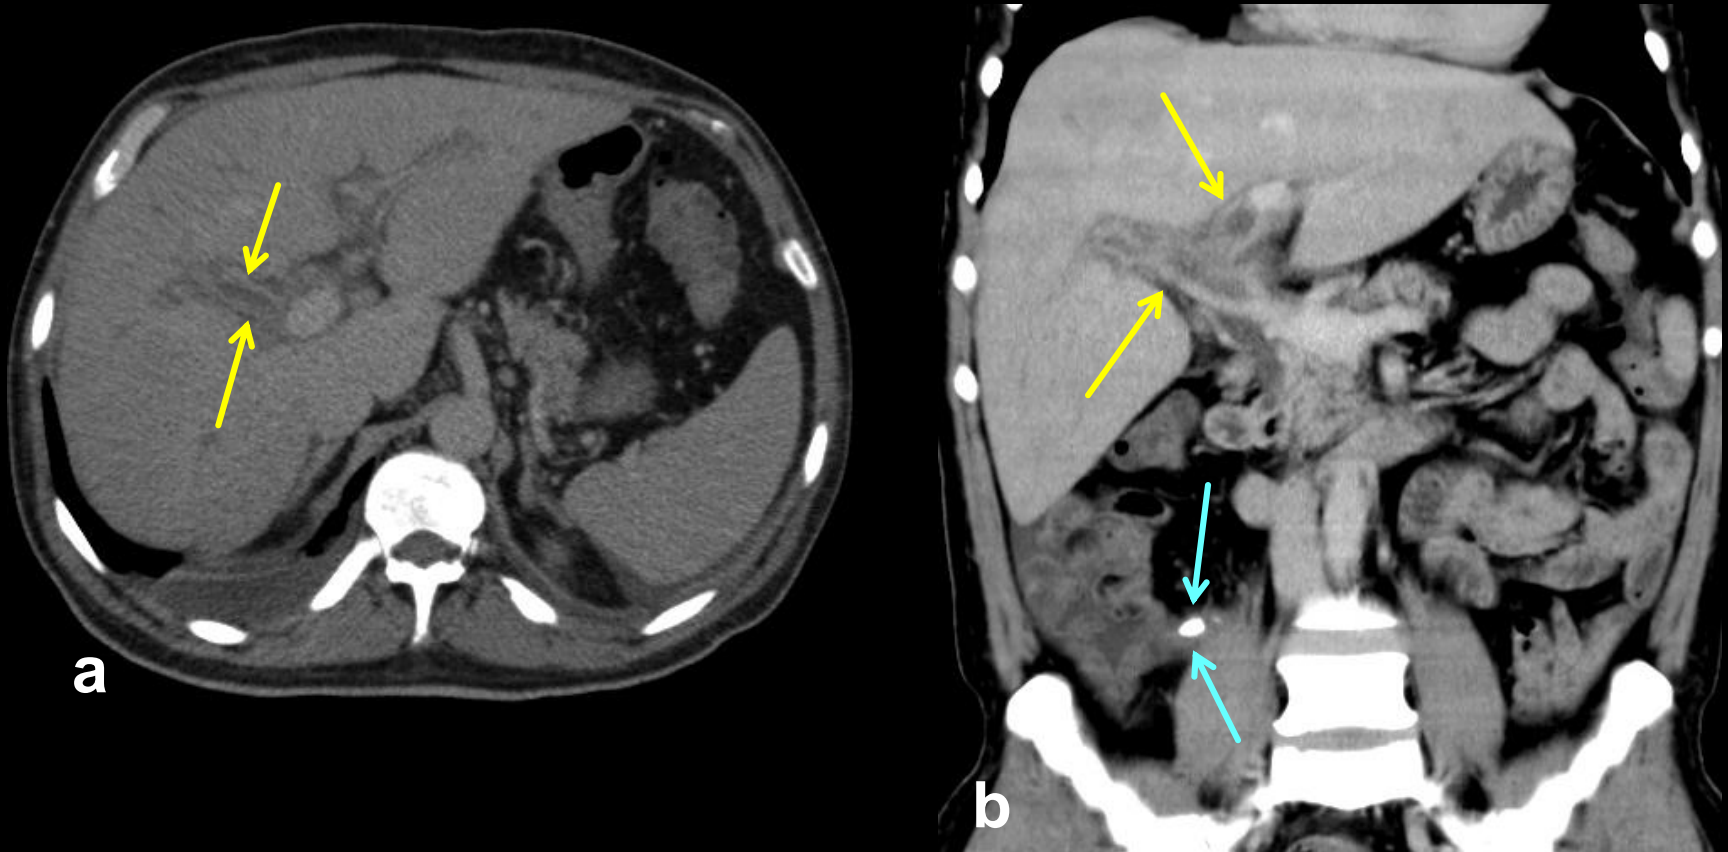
48-year-old man with appendicitis and septic thrombosis of portal vein. Transverse and coronal CT images (a,b) demonstrate enhancement and thickening of the walls of thrombosed portal veins (yellow arrows). Blue arrows point to thickened appendix with appendicolith.
